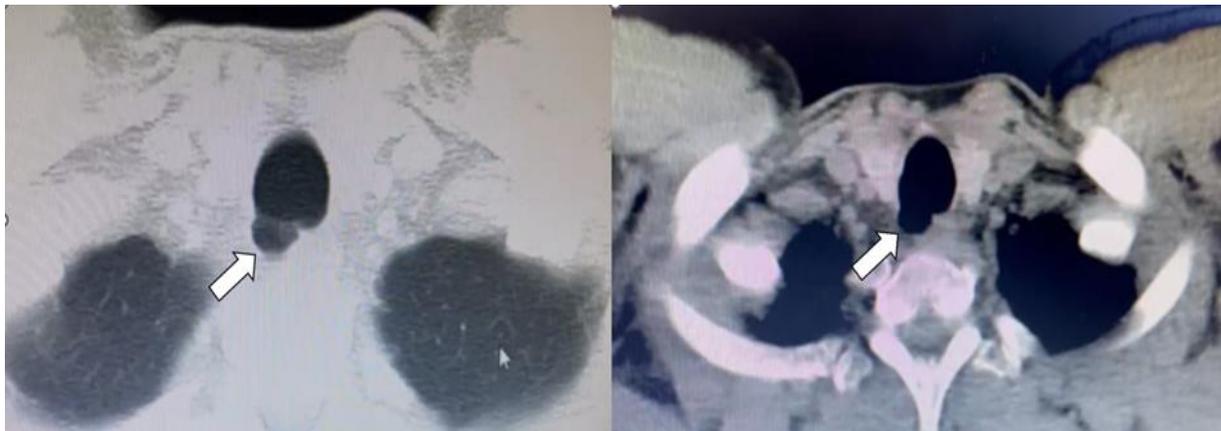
CT scan outlining tracheal diverticulum (arrow) at the right posterolateral trachea on parenchymal and mediastinal views.
